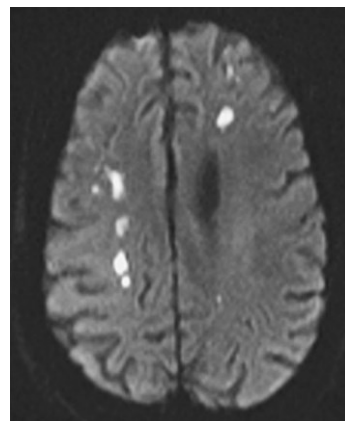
Brain MRI showing multiple areas of restricted diffusion.
